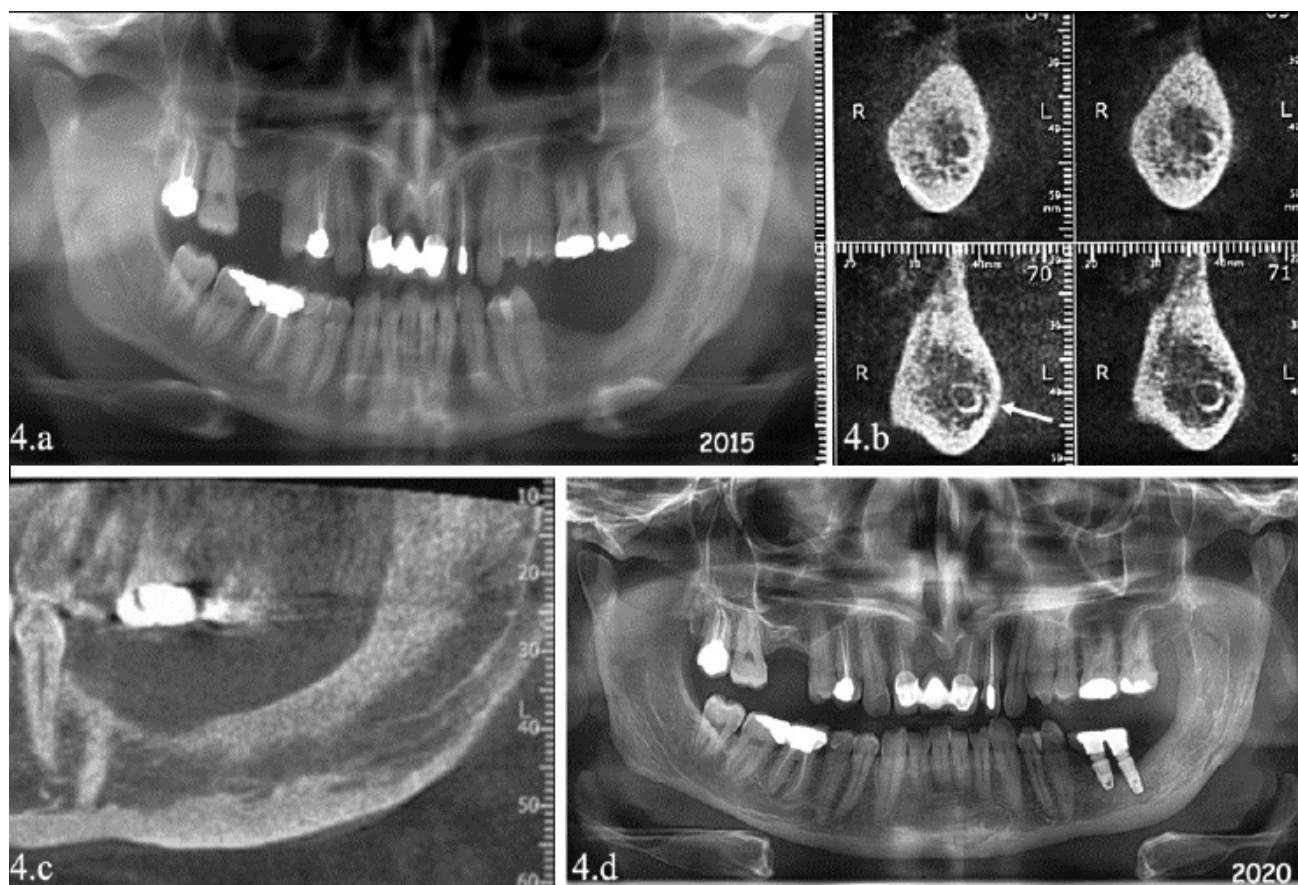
a. Eight-years (2015), after the third surgery: cropped panoramic radiograph showing complete remission of the mandibular bone. b. Para-axial reconstruction image of CT scan: complete bone formation and the new position of the mandibular canal (→). c. Sagittal reconstruction image of CT scan showing bone healing in the body, angle and ramus of the mandible. d. Panoramic radiograph, 18 years after (2020), showing complete remission of the mandibular bone with two-implant placed to restore the extracted molars.
